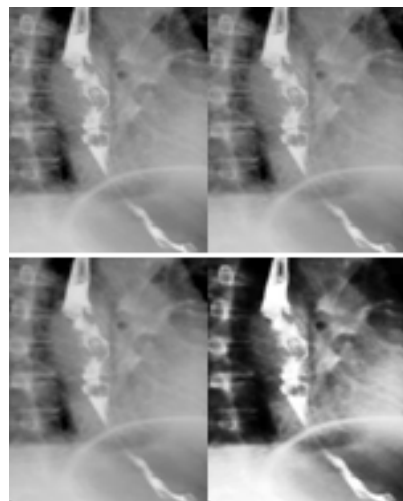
Preprocessing results of ulcerous esophageal X-ray. Upper left: Original image; Upper right: Color transformed; Lower left: Removed noise; Lower right: Enhanced.
